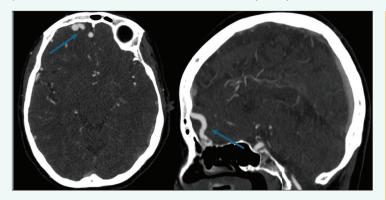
CT angiogram of the head axial (A) and sagittal (B) sections demonstrating a right-sided ectatic vein (arrow) emerging from the cribiform plate
